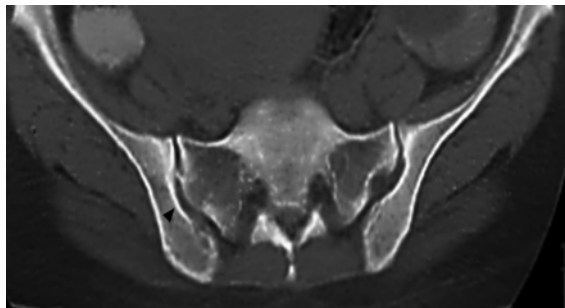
58-year-old woman with a crescent like iliac bony plate (arrowhead) unilaterally on the CT section.
